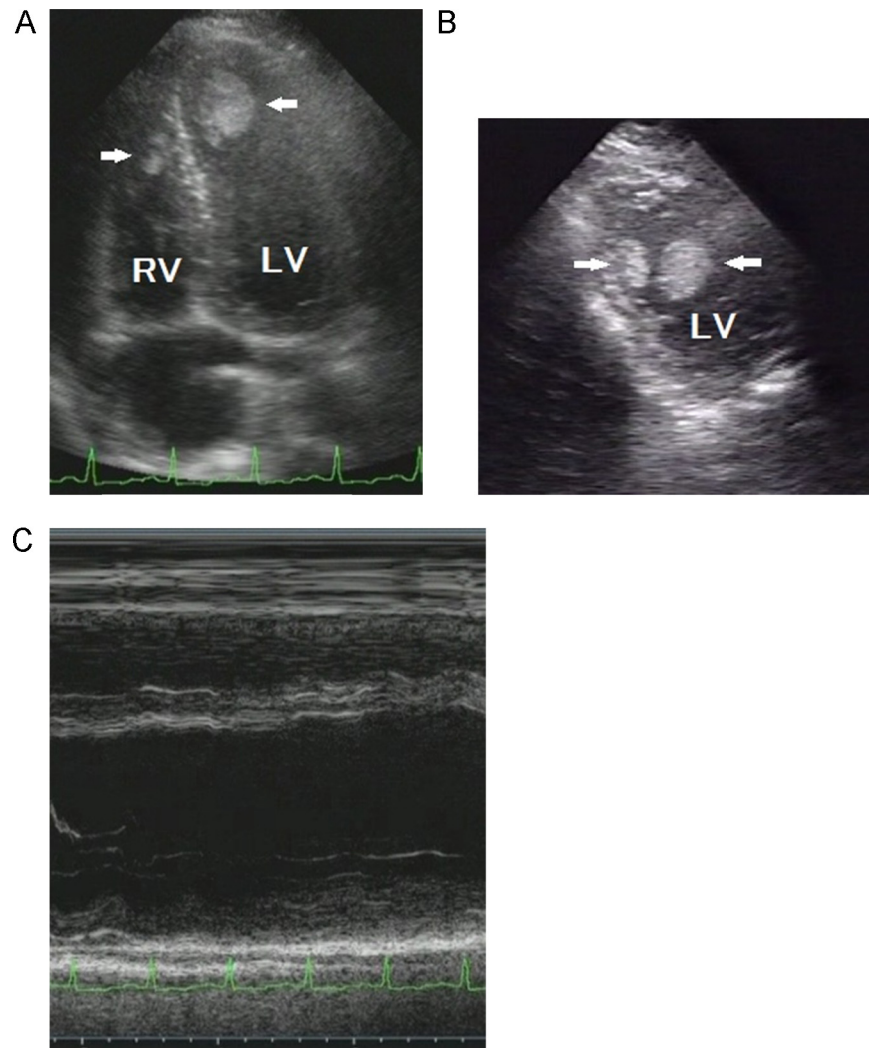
Transthoracic echocardiogram on admission. (A) An apical 4-chamber view of transthoracic echocardiogram on admission. (B) A short-axis view of transthoracic echocardiogram on admission. These images revealed massive thrombus in left ventricular apex (28 mm × 21 mm, 22 mm × 14 mm) and right ventricular apex (16 mm × 11 mm). (C) M-mode echocardiogram on admission. Left ventricular diastolic dimension was 65 mm, and ejection fraction was 29%. LV, left ventricle; RV, right ventricle; Arrow, thrombus.
